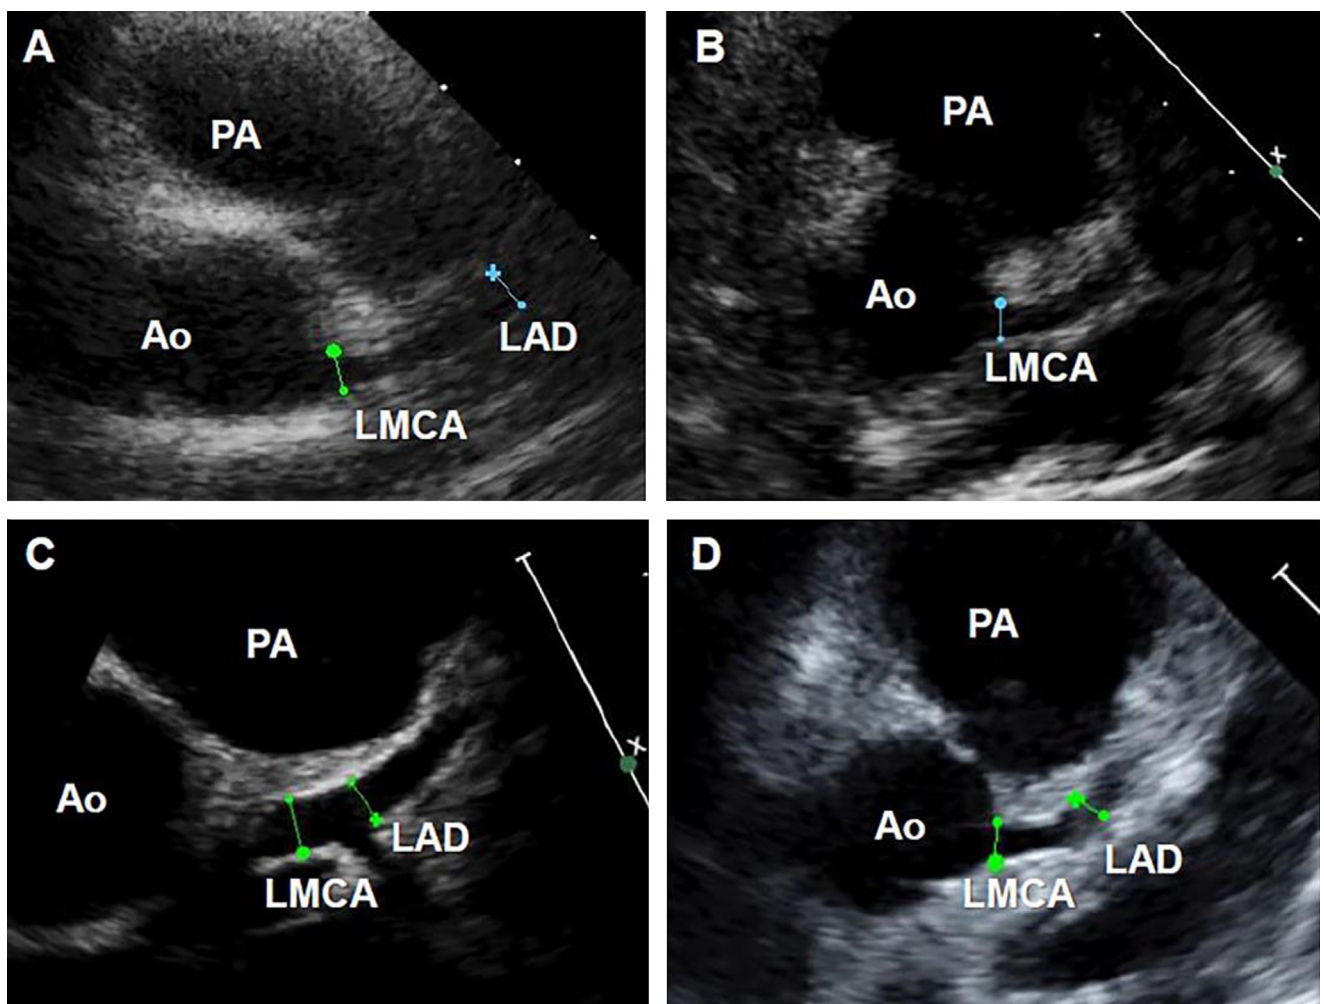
Echocardiogram stills from Case 1 (A), 2 (B), 3 (C), and 4 (D) in the parasternal short axis. (A), (C), and (D) dilated left main coronary artery (LMCA) and left anterior descending coronary artery (LAD). (B) Dilated left main coronary artery (LMCA).
